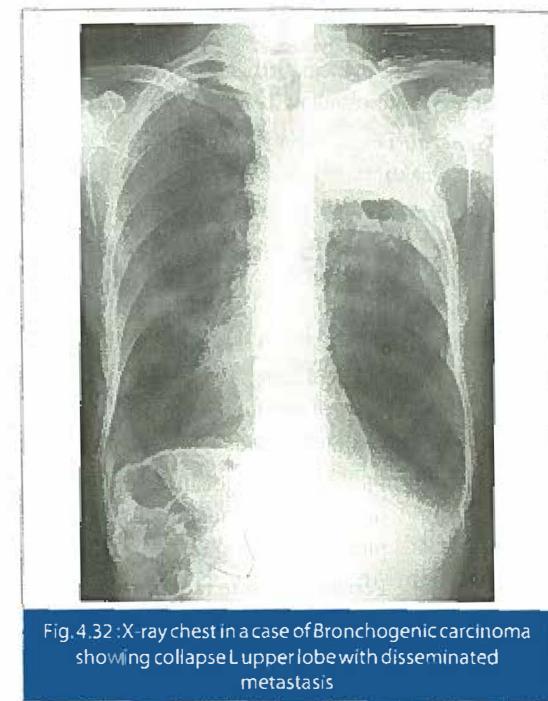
X-ray chest in a case of Bronchogenic carcinoma showing collapse of upper lobe with disseminated metastasis
